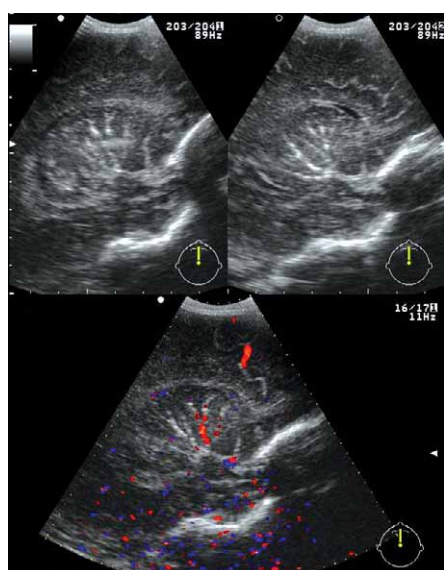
(above) and 1b (below). Ultrasound markers of LSV with hyperechoic streaks and spots and TFCD visualization of blood vessels in the echogenic area.
